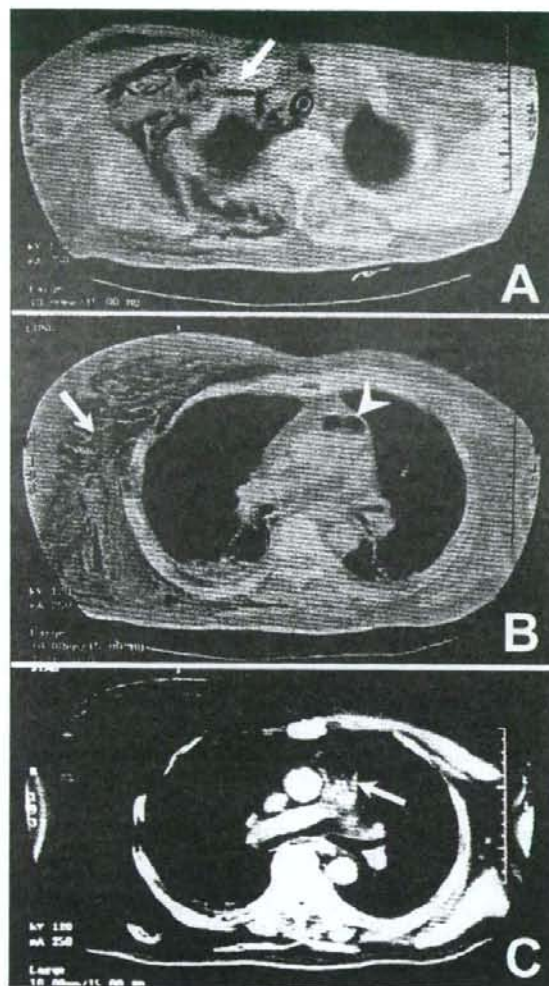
Chest CT scan imaging 20 min after arrival. (A) Right subclavian vein filled with entrapped gas (arrow). (B) Marked subcutaneous emphysema with destruction of muscle tissue around right chest (arrow) and massive gas entrapped in the pulmonary artery (arrowhead). (C) CT scan revealing many bubbles (arrow) below the massive gas entrapment in the pulmonary artery.
